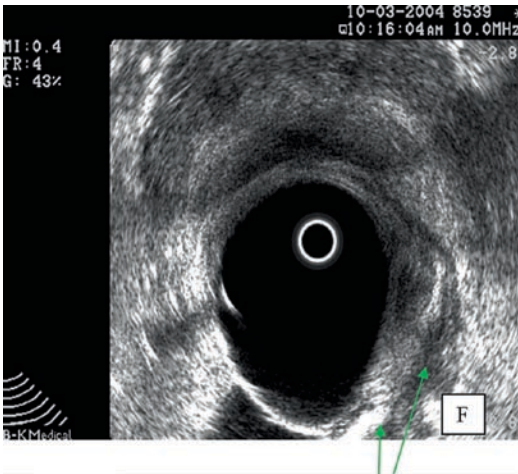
Endorectal ultrasonographic recurrent rectal cancer with finger-like projections (arrows) into extrarectal fat (hyperechoic area marked F).
